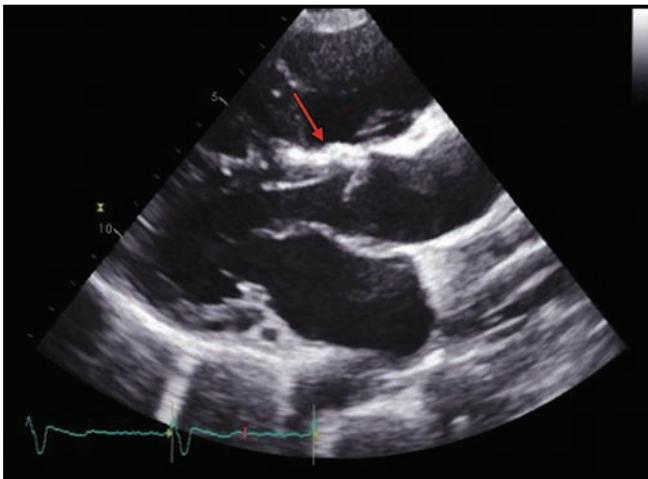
Parasternal long axis view showing an increased echogenicity (red arrow) in the site of surgical closure of ventricular septal defect by patch.
